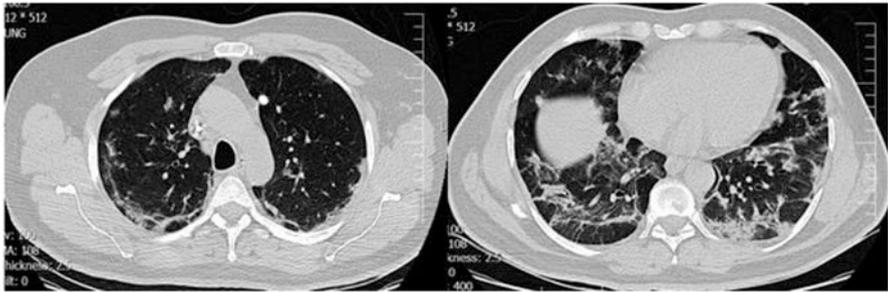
Two axial chest CT scans without contrast show bilateral and multifocal patchy subpleural ground-glass opacities (GGOs) in a patient with COVID-19 pneumonitis
